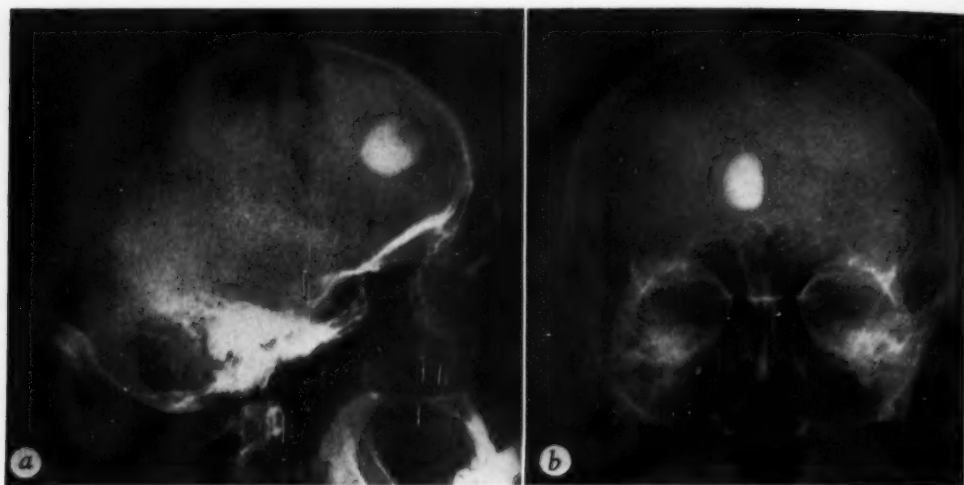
Left frontal parasagittal meningioma. *a*. Calcification within the tumor is so compact and homogeneous that the entire mass is outlined by the zone of calcification. *b*. Antero-posterior roentgenogram revealing parasagittal situation of calcified left frontal meningioma.
